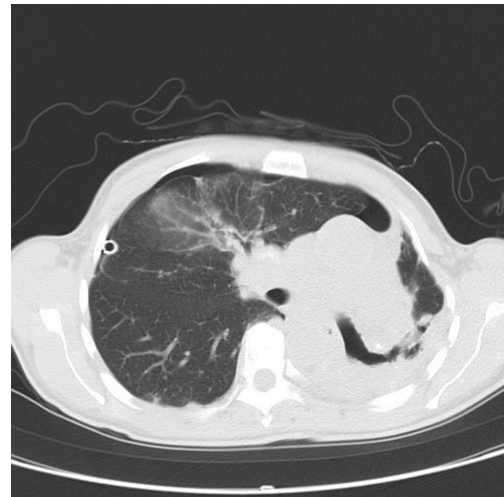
Chest computed tomography demonstrating extensive fibrotic destruction, cavitation, and severe parenchymal loss of the left lung.
